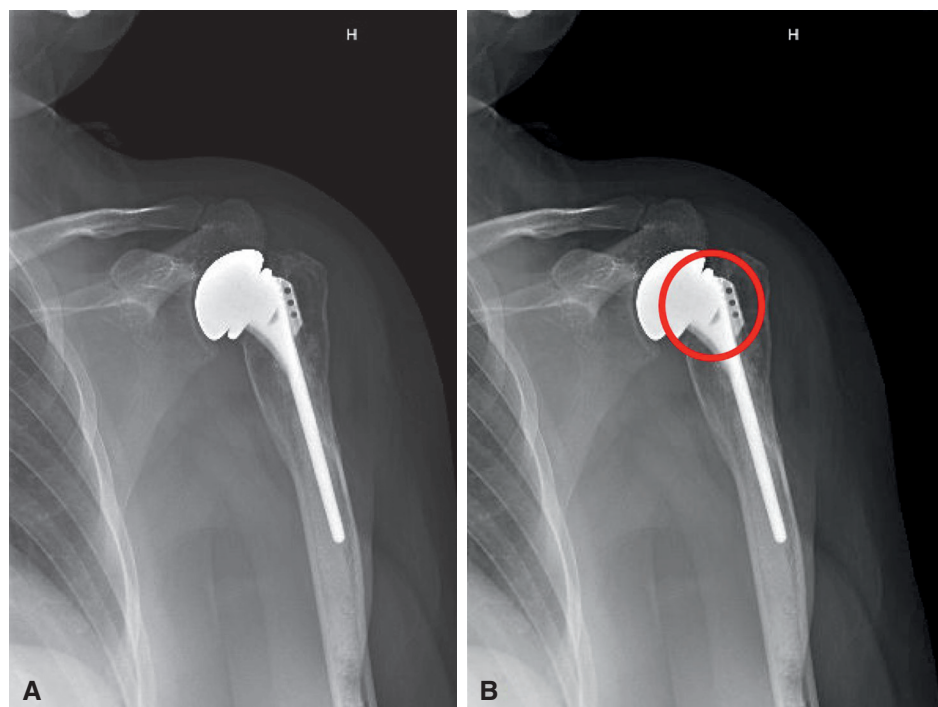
This AP x-ray is of a patient who had a hemiarthroplasty performed for proximal humerus fracture approximately 20 years prior (A). Using a “best-fit” circle method as described by Alolabi and colleagues,³⁸ it appears that the implant was oversized and overstuffing the joint (B). At the time of revision surgery the patient was completely rotator cuff–deficient and was revised to a reverse shoulder arthroplasty. [AU2]
